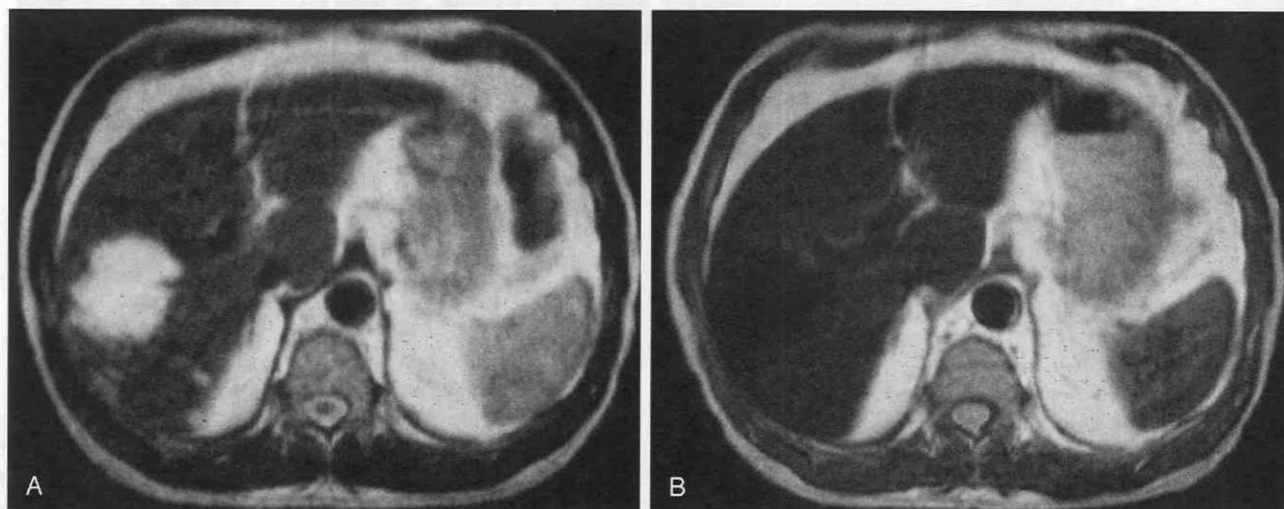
Hemangioma. A, Unenhanced T2-weighted image demonstrates a 4-cm lesion in the right hepatic lobe. B, T2-weighted image after ultra-small superparamagnetic iron oxide (USPIO) administration demonstrates signal loss, reflecting blood pool effects.
